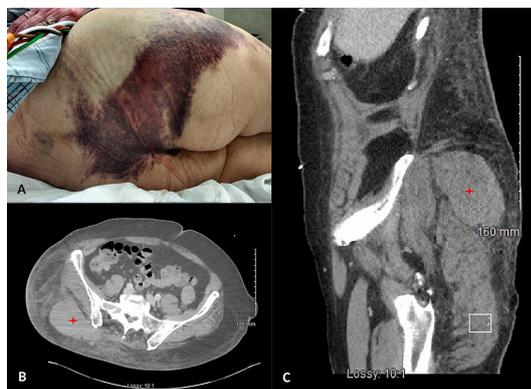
(A) Huge ecchymosis of the skin noted over lower back and right buttock. (B,C) Axial and sagittal view of CT pelvis showing extensive haematoma formation in the right gluteal region.
